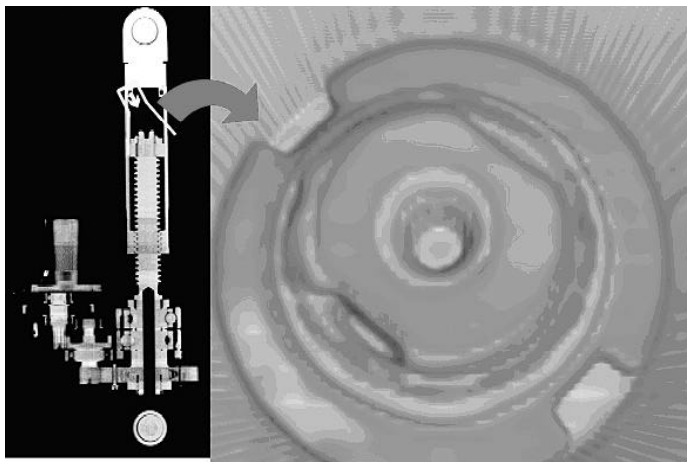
CT image of end fastener assembly from inside the screw housing.
